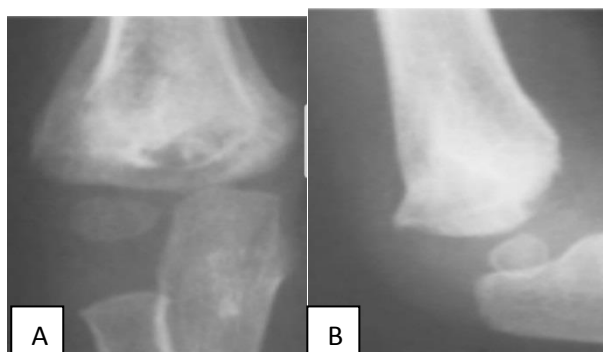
Radiograph of a united displaced supracondylar fracture after fixation with two lateral Kirchner wires at follow up. (A) Anteroposterior view, (B) lateral view.
